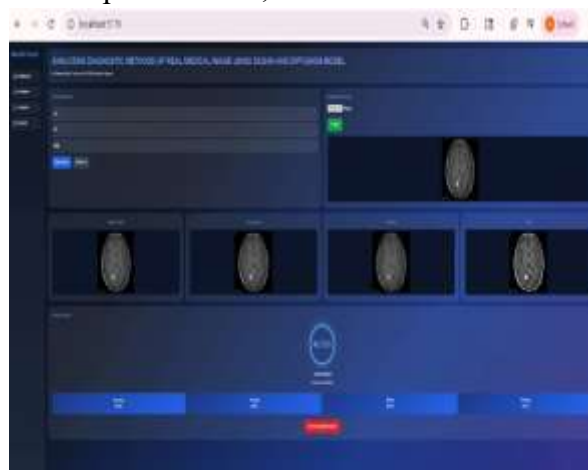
Implementation result for Brain Tumor MRI classification using the proposed generative augmentation framework.
